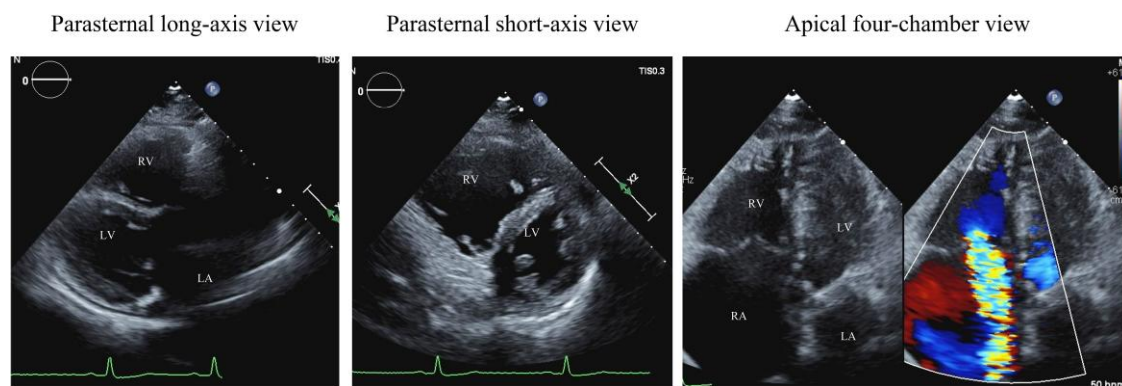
Transthoracic echocardiography at first admission, showing right ventricular and right atrial dilatation, and severe functional tricuspid regurgitation without left ventricular hypertrophy.
